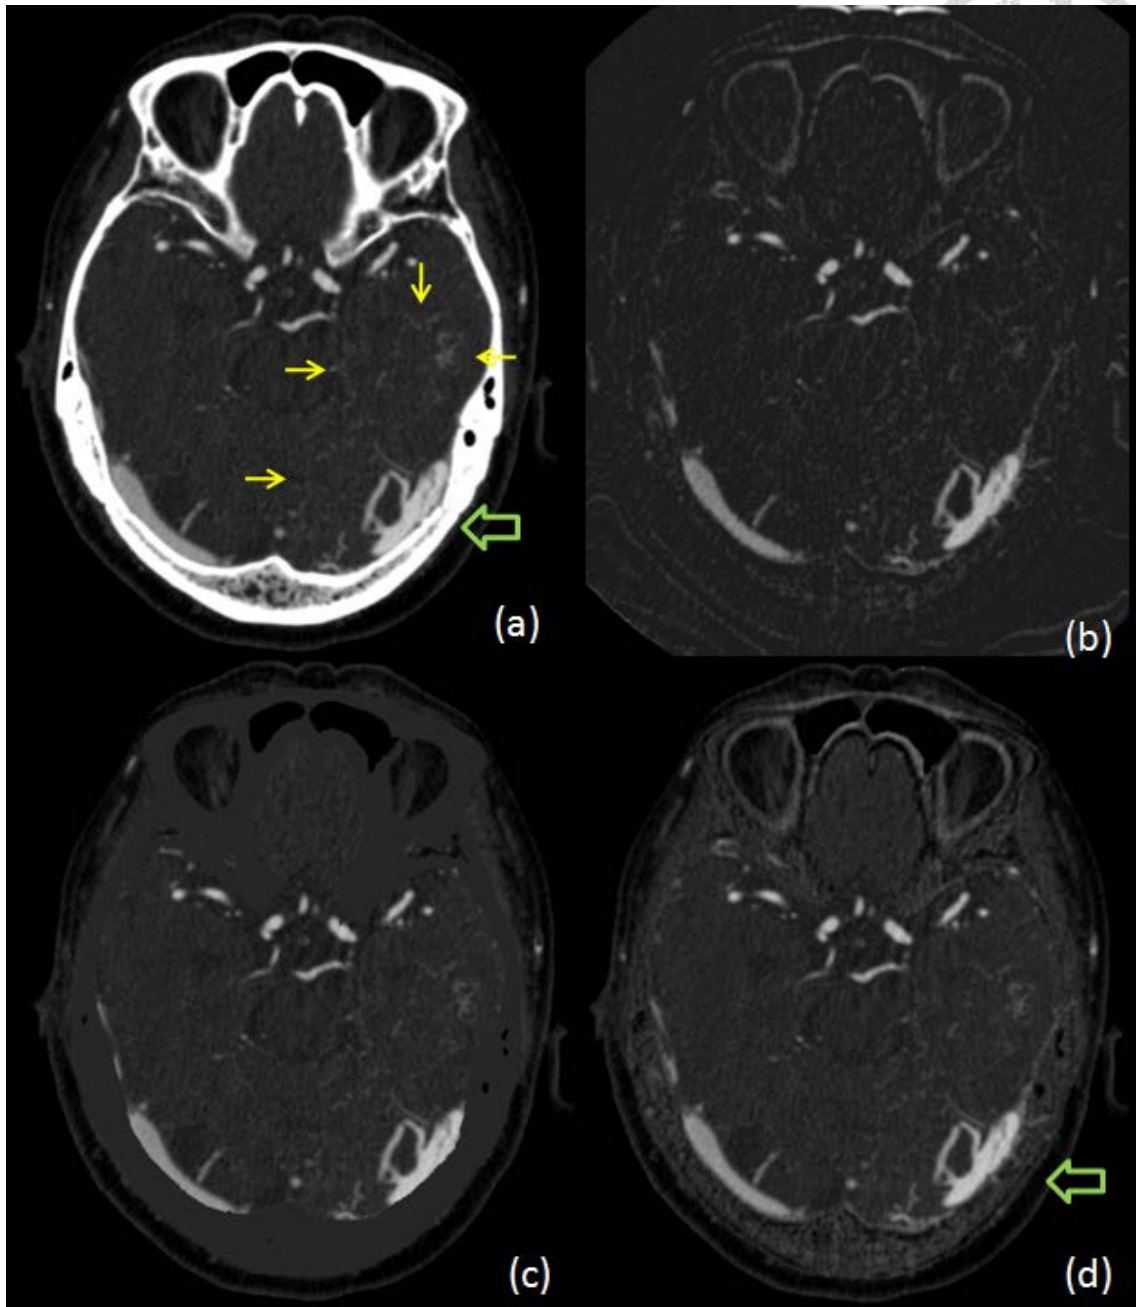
Advantage of hybrid bone subtraction CTA (hybrid CTA) (a) unprocessed CTA image showed early enhancing isolated left transverse sinus (large arrow) and multiple engorged medullary veins in left temporal lobe and left cerebellum (surrounded by small arrows). (b) subtraction CTA increased noises in the brain parenchyma, the engorged medullary veins were masked by noise. (c) MMBE CTA masked the information in and adjacent to bones. (d) hybrid CTA preserved the information in brain parenchyma, and added information in the bones (large arrow).
